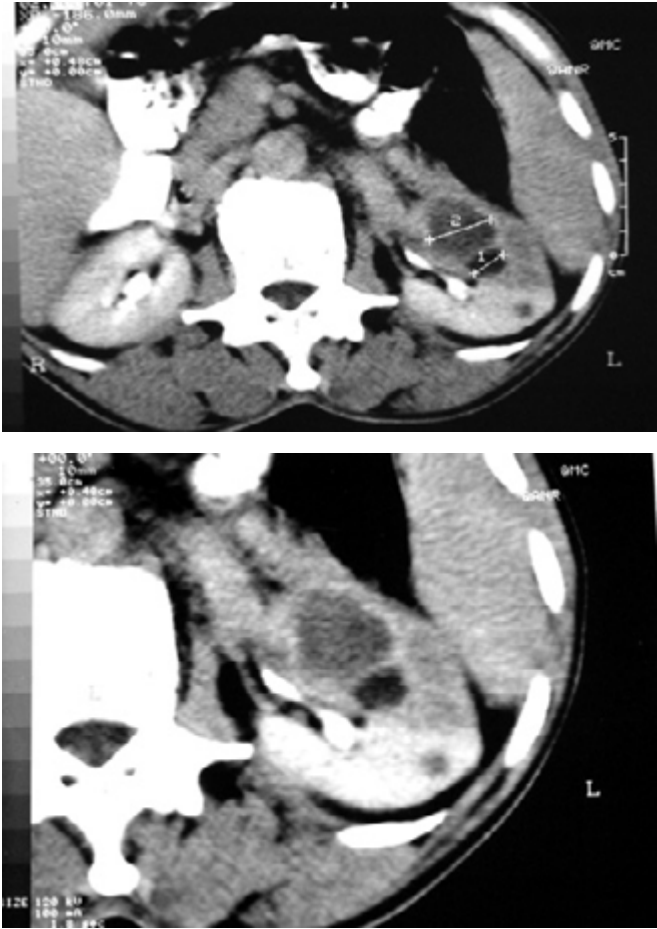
a) Abdominal contrast-enhanced CT scan demonstrating 4.5 x6.5 cm renal mass in the left kidney. The mass without calcification. b) Abdominal contrast-enhanced CT scan showing heterodense mass without lymphadenopathy and renal vessels involvement, although perirenal fat was involved.
